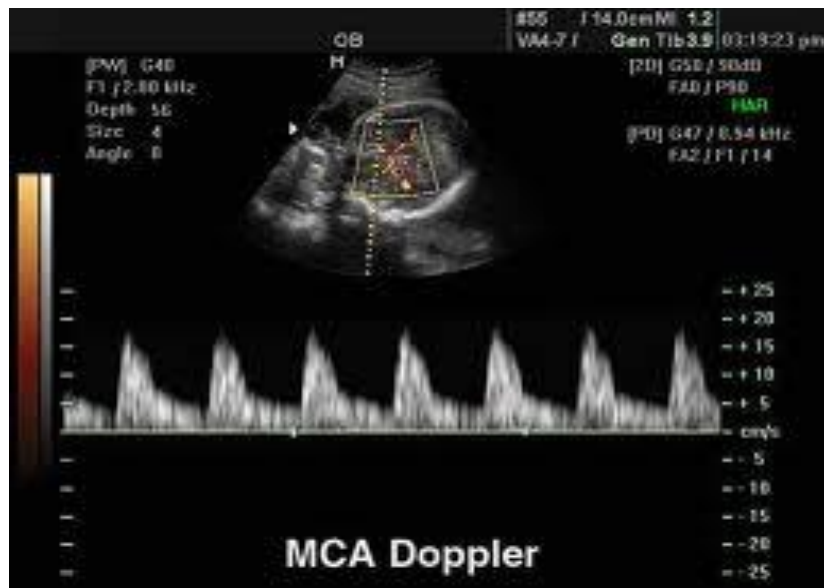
NORMAL MCA DOPPLER
